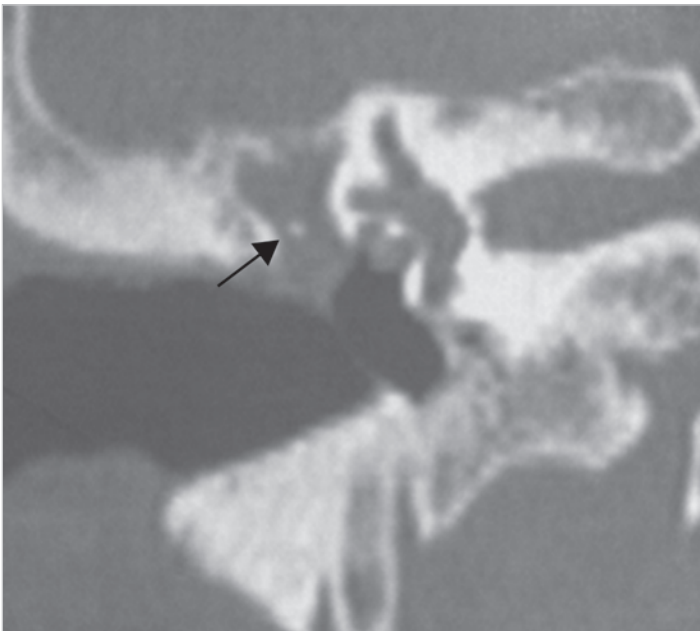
CT scan of the same case, coronal view. Epitympanic cholesteatoma severely erodes the short process of the incus.
